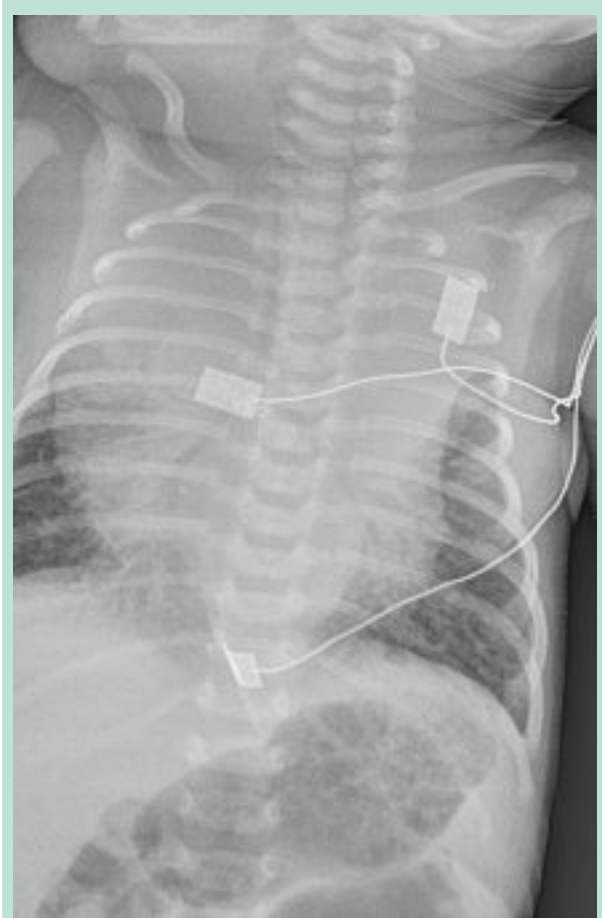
Thorax X-Ray study showing a mediastinum mass which provoke respiratory distress in newborn.
